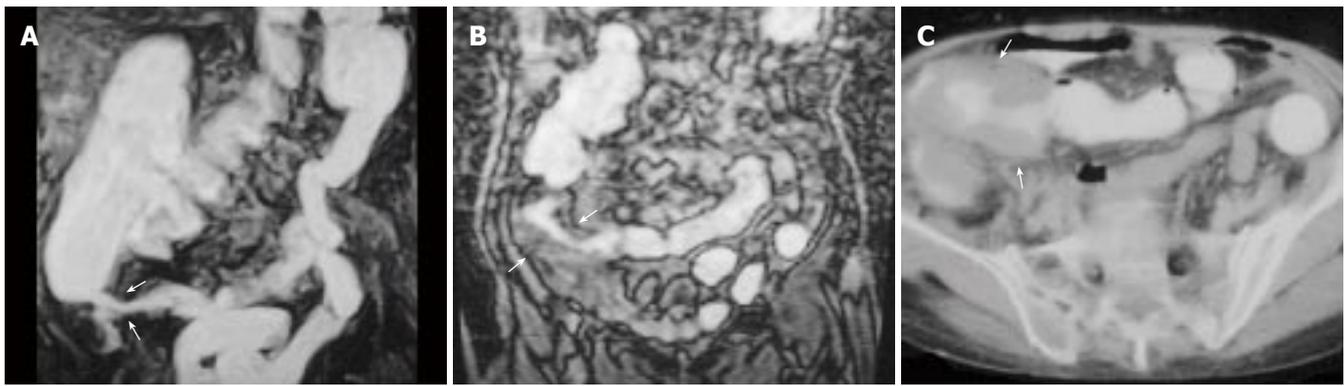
A 70-year-old man with inflammatory disease in the ileocaecal region. A: MR colonography MIP (maximum intensity projection) image; B: coronal plane MR colonography raw data image; C: axial CT image showing asymmetrical, irregular wall thickening of the ileocaecal region (arrows) and serpinginous strands extending into soft tissue due to inflammatory disease.
